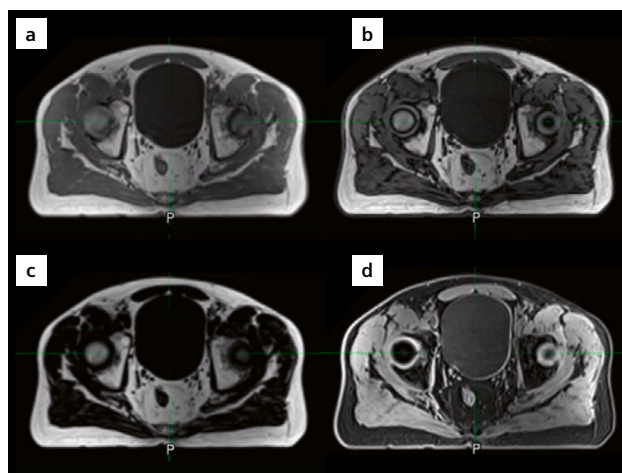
Four MR contrasts generated by the T1 VIBE-Dixon scan protocol (a) in-phase (IP), (b) out-of-phase (OP), (c) fat, (d) water. Only a and b are needed for Synthetic CT postprocessing.
